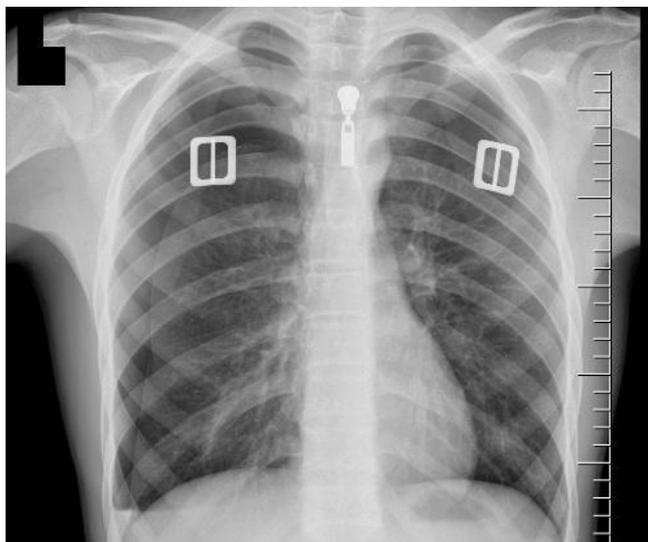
Chest X-Ray shows bilateral pneumothorax
